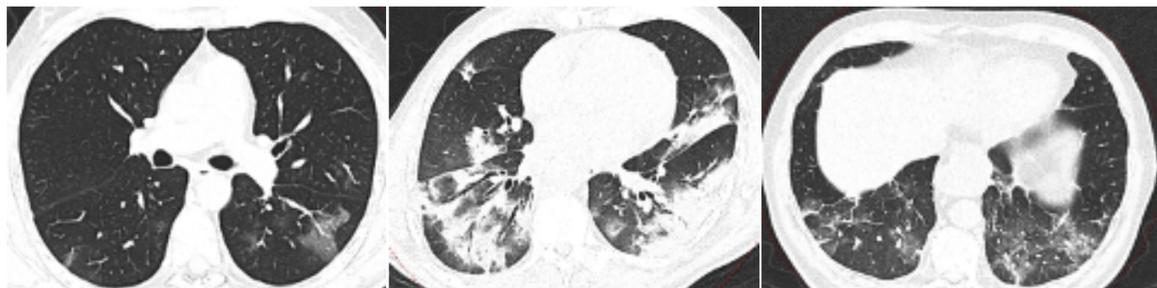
(a) Chest CT scan shows bilateral ground glass opacities (GGOs) in the apical segments of both lower lobes and in the right upper lobe; (b) Chest CT scan shows bilateral large consolidations with air bronchogram in both lower lobes. Less extensive consolidations can be observed in the left upper lobe and in the middle lobe. A solid nodule surrounded by a ground glass halo in the middle lobe can also be observed; (c) Chest CT scan shows thickened pulmonary interstitial structures, with reticular pattern and fibrous stripes in both lower lobes.
